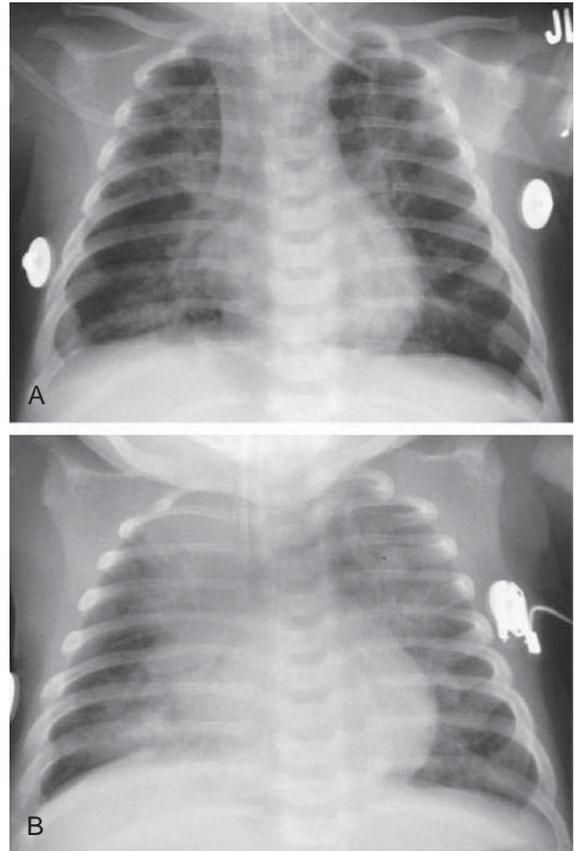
A, Radiographic findings characteristic of respiratory syncytial virus pneumonia in a 6 mo old infant with rapid respirations and fever. Anteroposterior radiograph of the chest shows hyperexpansion of the lungs with bilateral fine air space disease and streaks of density, indicating the presence of both pneumonia and atelectasis. An endotracheal tube is in place. B, One day later, the anteroposterior radiograph of the chest shows increased bilateral pneumonia.
